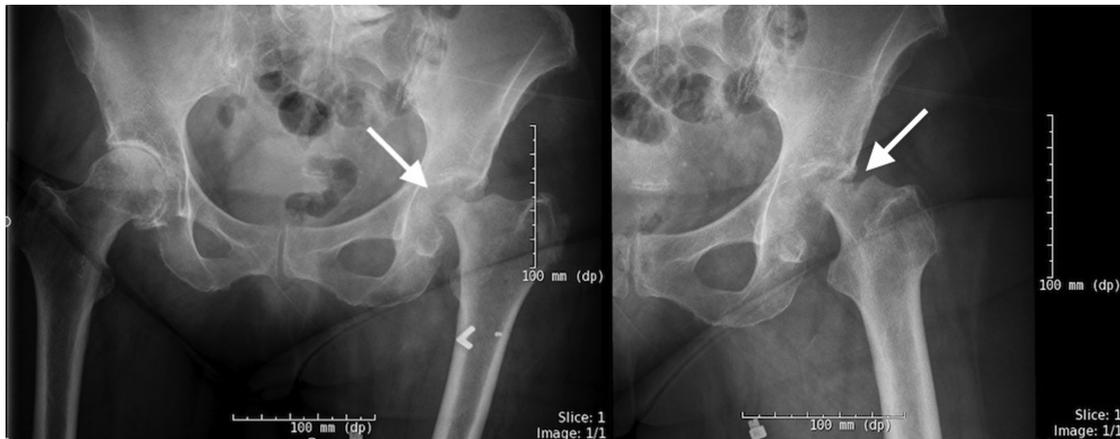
Anteroposterior pelvis and lateral x-ray studies of the left hip during emergency department showing destructive arthropathy of the left hip (5 weeks after hip injection).
